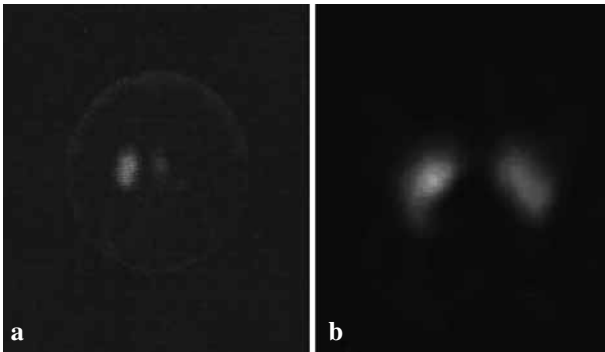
[^{123}I]fluopane SPECT (DAT-Scan) showing the asymmetrical tracer binding in the pre-operative scan (a) and the normalization of signal in the scan repeated 6 months after removal of the meningioma (b).
